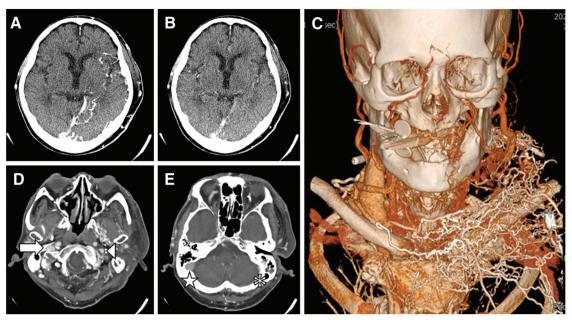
Contrast CT images. In early phase of CTP source image, cerebral veins of left hemisphere were enhanced (A). In late phase of CTP source image, cerebral arteries were enhanced (B). In 3D CTA, both right IJV and superficial veins of chest wall were enhanced but left IJV was not enhanced (C). In source images of 3D CTA, compared with right IJV (arrow), left IJV (arrowhead) was hypoplastic (D). Similarly, left sigmoid sinus (asterisk) was hypoplastic compared with right sigmoid sinus (star) (E). CTP: CT perfusion; IJV: internal jugular vein
